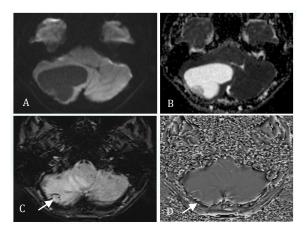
MRI axial sections
